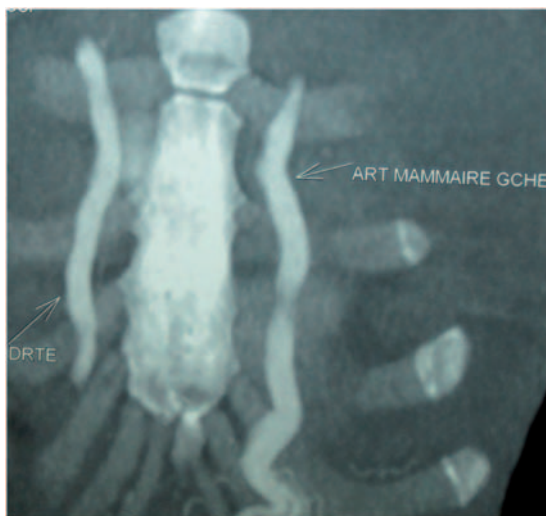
Chest computed tomography showing severe dilatation of the internal mammary arteries, tortuous and most pronounced on the left side.
